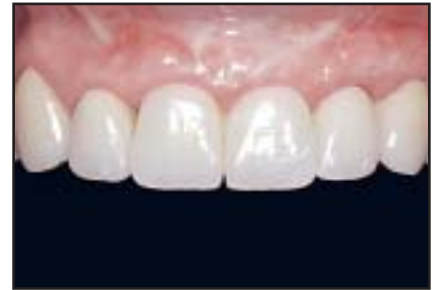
Patient 1.Figs 1a to 1c Clinical and radiographic appearance of a 55-year-old woman who presented with esthetic and masticatory disturbances.Fig 1d (left) Periapical radiograph of the anterior teeth after orthodontic therapy. Both central incisors and the left lateral incisor were planned to be replaced by an implant-supported restoration.Fig 1e (above center) Anterior view of the result. Esthetics and function are maintained. An interdisciplinary approach was needed.Fig 1f (above right) Posttreatment orthopantomograph of the patient. Positions of the teeth and implants are optimal.Fig 1g (above left) The pontic site shows excellent shape owing to the submerged root.Fig 1h (above center) The definitive restoration looks natural. The submerged root of the right maxillary central incisor maintains the surrounding alveolar bone and soft tissues of the pontic in the most coronal position. A normal pontic is not typically able to reproduce these ideal tissue frames and papilla heights because of a lack of needed underlying bone support.Fig 1i (right) Posttreatment periapical radiograph obtained 27 months after root submergence. The submerged root maintains an ideal mesiodistal alveolar bone level.
